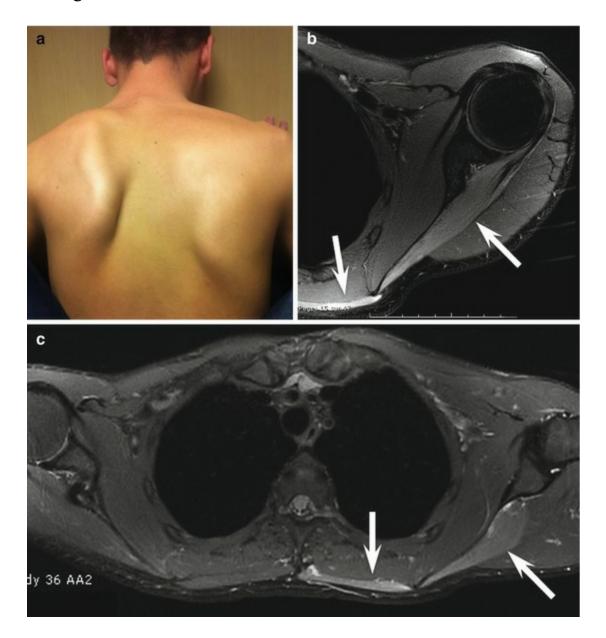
A 22-year-old man with Parsonage-Turner syndrome due to a left suprascapular and accessory nerves palsy. (a) Photograph of the patient showing a winging scapula of the left shoulder. (b) Axial fat-suppressed T2-weighted MRI shows muscle edema of the infraspinatus and trapezius muscles (arrows). (c) Axial water-imaging with a three-point Dixon MRI shows the muscle edema of the infraspinatus and trapezius muscles (arrows). Note the good signal homogeneity of the image
